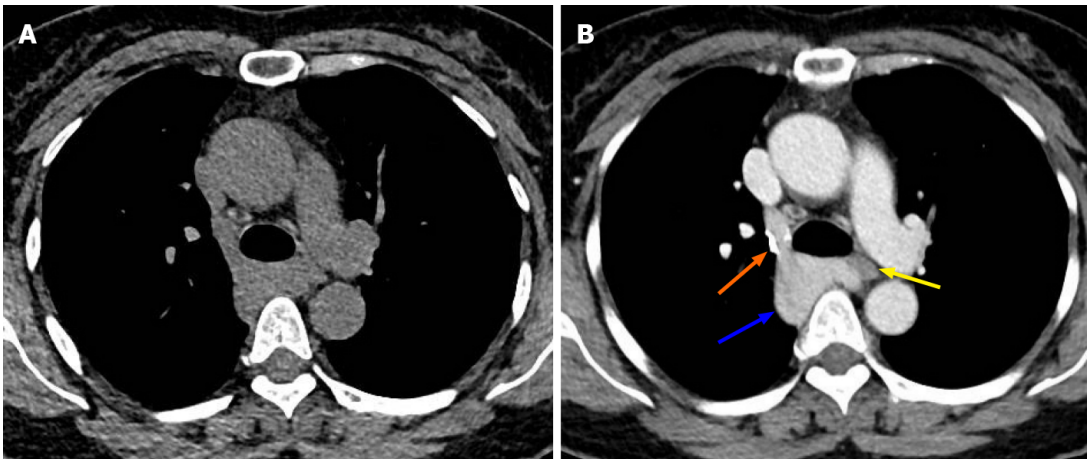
Tumor imaging by chest computed tomography. A: Chest computed tomography showed a soft-tissue mass in the right posterior mediastinum; the mass was approximately 4.2 cm × 3.7 cm × 2.6 cm in size and showed unclear boundaries with the esophagus and compression of the trachea; B: Enhanced scanning showed that the azygos vein arch widened, the contrast agent remained in the azygos vein arch, the tumor exhibited delayed enhancement, and the internal density was uneven (blue arrow). In the venous phase, the tumor was connected to the superior vena cava, and the degree of enhancement was the same as that of the superior vena cava. The boundary between the tumor and the esophagus was clear. Note the azygos vein valve (orange arrow). The esophagus was compressed by the azygos vein aneurysm (yellow arrow).
